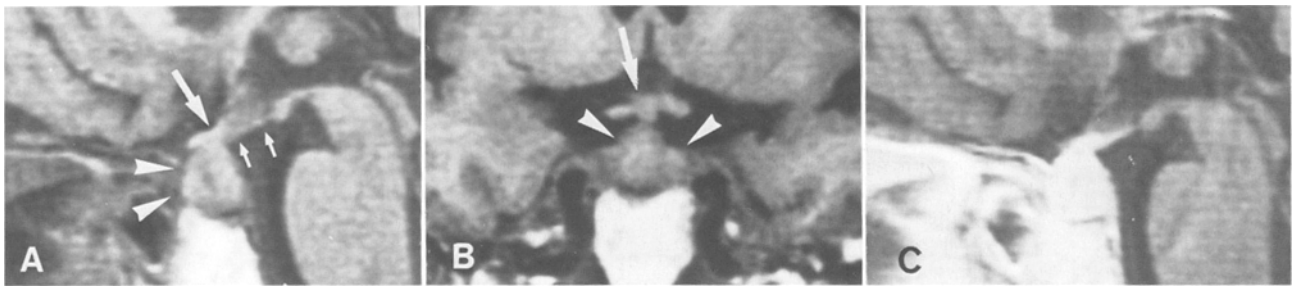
Case 4. Sagittal (A) and coronal (B) T1-weighted MR images reveal an iso-intense mass in the sell turcica (arrow-heads) associated with a thickened pituitary stalk (large arrow) and infundibulum (small arrows). These lesions were homogeneously enhanced with Gd-DTPA (C)
